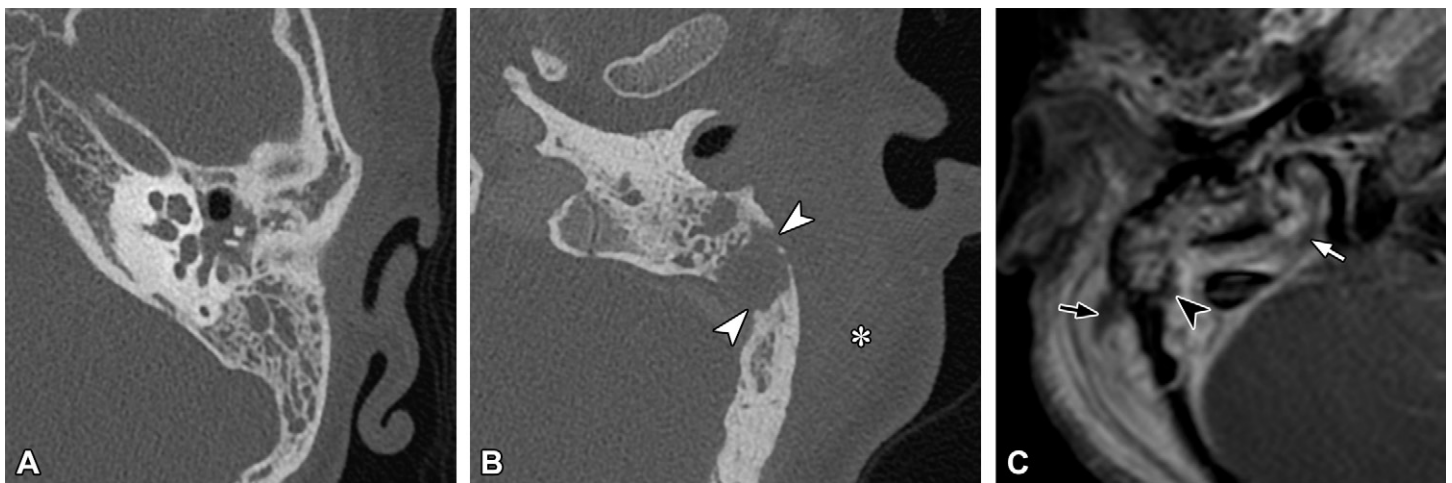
Imaging of the temporal bone in three pediatric patients. (A) Axial temporal bone CT image shows nonspecific mastoid and middle ear fluid in a 7-year-old boy with eustachian tube dysfunction. Note the intact mastoid septa and cortex. (B) Axial temporal bone CECT image in a 12-year-old boy shows coalescent mastoiditis with erosion of the mastoid septa and mastoid cortex (arrowheads) and overlying postauricular swelling (*). (C) Contrast-enhanced T1W FS MR image shows complicated otomastoiditis in a 4-year-old boy with ear pain, with jugular bulb and sigmoid venous sinus thrombus (white arrow), small epidural abscess (arrowhead), and subperiosteal abscess with surrounding cellulitis (black arrow).
